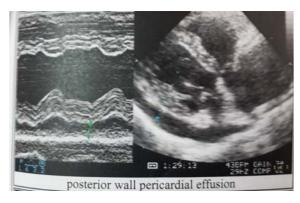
Echocardiography in the patient prevailed posterior wall pericardial effusion.
